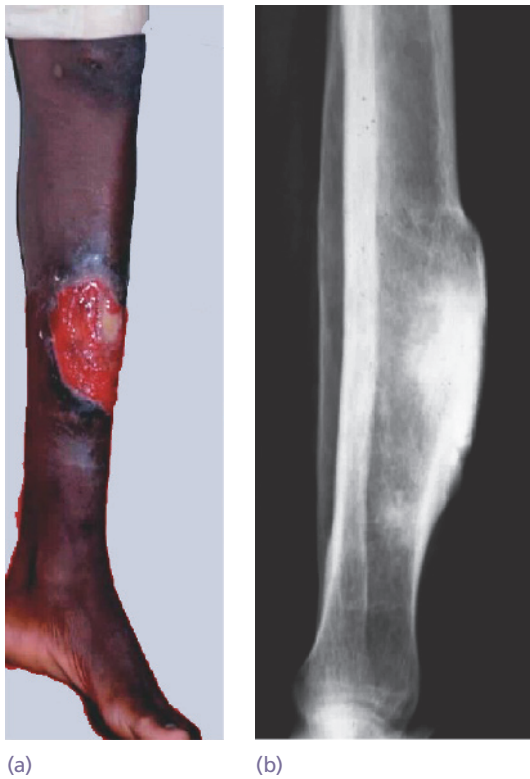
Tropical ulcer (a) What started as a small ulcer has turned into a large spreading lesion. (b) The X-ray shows the typical marked periosteal reaction in the underlying bone.
